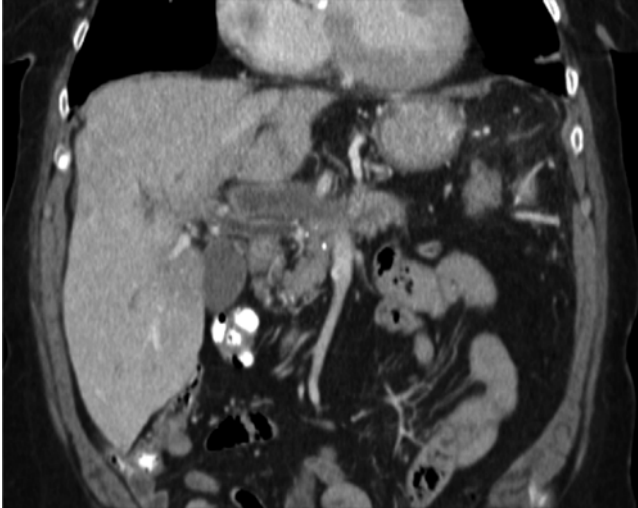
CT showing thrombus in the superior mesenteric vein
